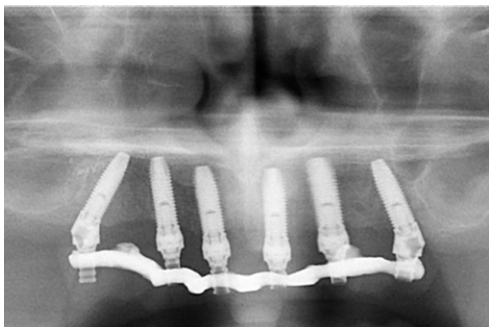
Radiographic control.
